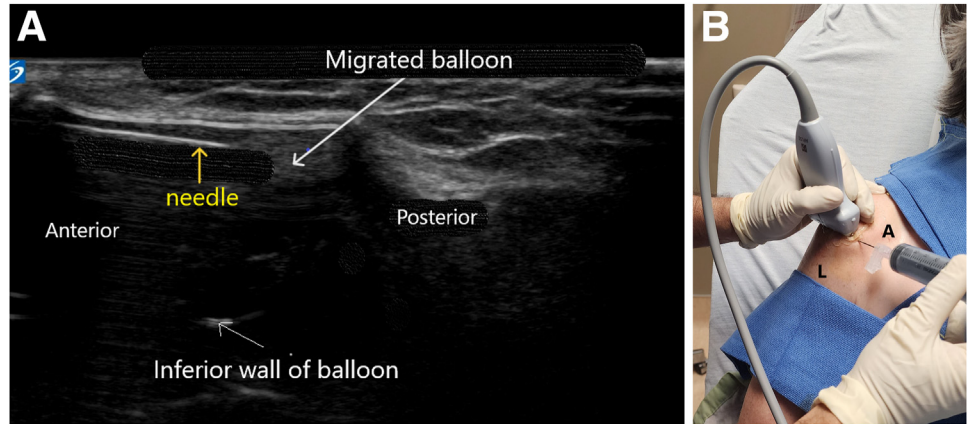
Ultrasound image of the right shoulder of the same patient. The transducer is oriented in the sagittal plane with anterior to the left and posterior to the right. Ultrasonic imaging of the symptomatic bulge reveals an anechoic mass in the subdeltoid space consistent with a fully inflated displaced balloon (arrow).
